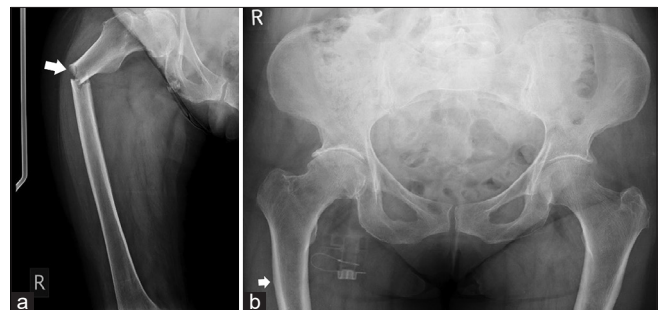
(a) A 75-year-old female presented with traumatic right hip pain. The pelvic radiograph demonstrated a displaced and laterally angulated, transverse fracture through the proximal shaft of the right femur (solid white arrow). (b) Pelvic radiographic study conducted 5 years earlier, showed subtle thickening of the lateral subtrochanteric cortex of the right femur (solid white arrow).
